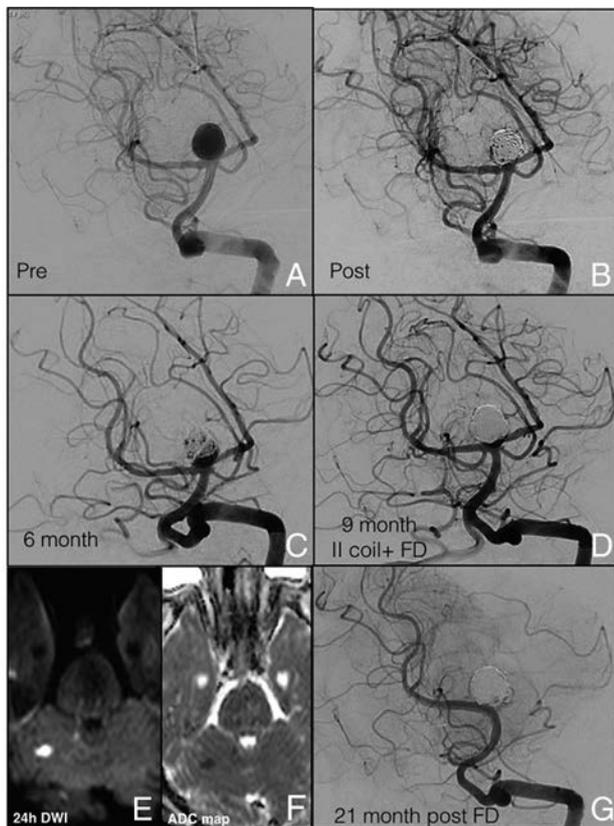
A, DSA shows a ruptured large BAA (10 × 10 mm; neck, 4.4 mm). B, Aneurysmal embolization was performed with the balloon-remodeling technique. C, Six-month DSA follow-up shows a significant neck recanalization (5 mm × 6 mm). D, At the 9-month follow-up, a second coiling remodeling technique associated with the deployment of a FRED flow-diverter stent across the right PCA was performed. E and F, The 24-hour postprocedural MR imaging, with DWI and ADC map, shows the presence of a small ischemic right cerebellar lesion. G, At 21-month DSA follow-up, both covered superior cerebellar arteries were not visualized, and the persistence of complete BAA occlusion was confirmed (mRR class I; mRS, 0).
